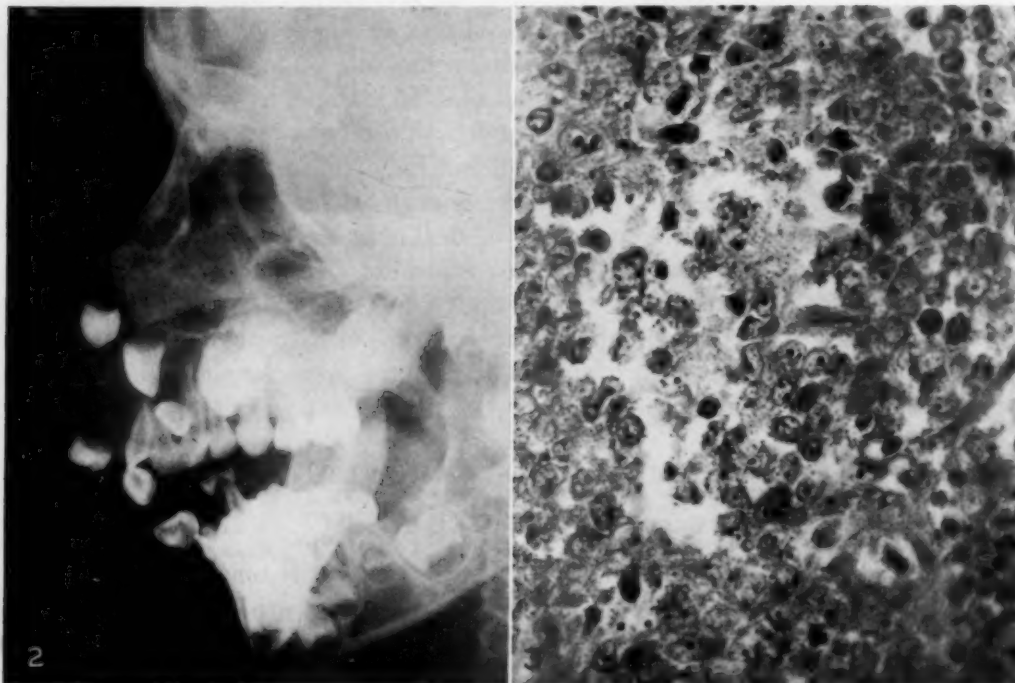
Case 1. Lateral radiograph of Case 1, showing mass of soft tissue density with misplaced unerupted permanent teeth.
